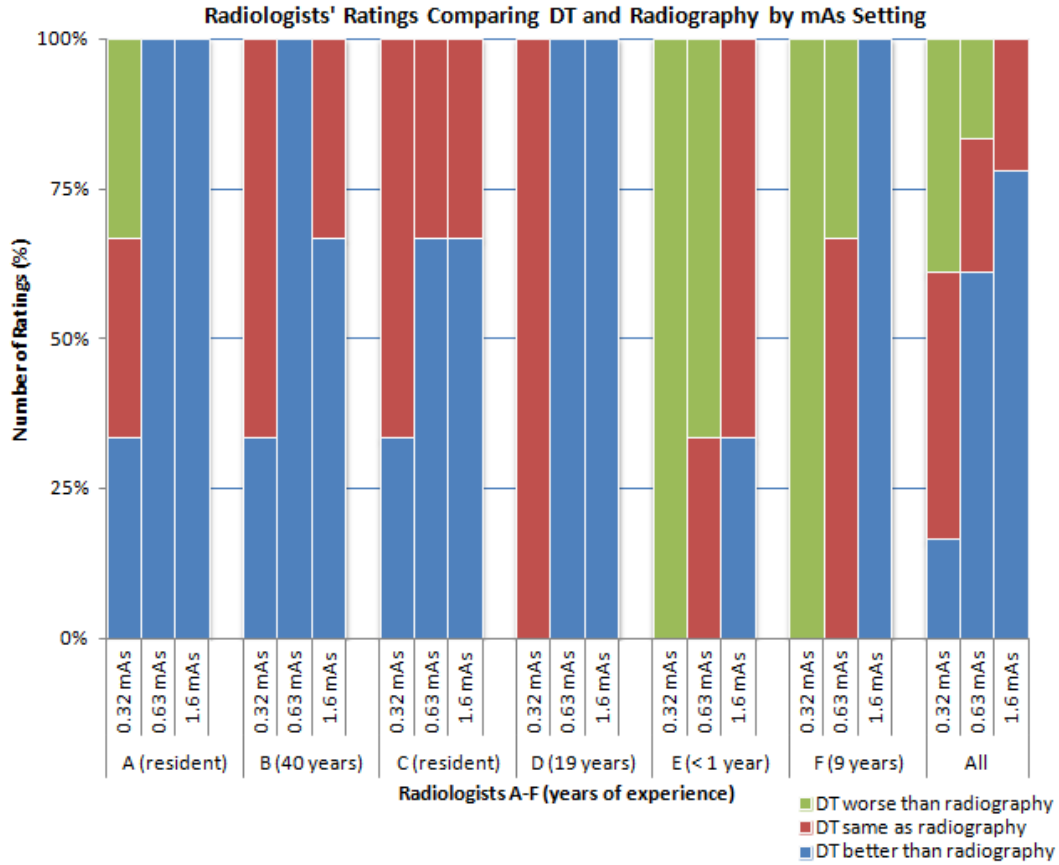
Graph showing radiologists' responses when comparing DT to radiographs
